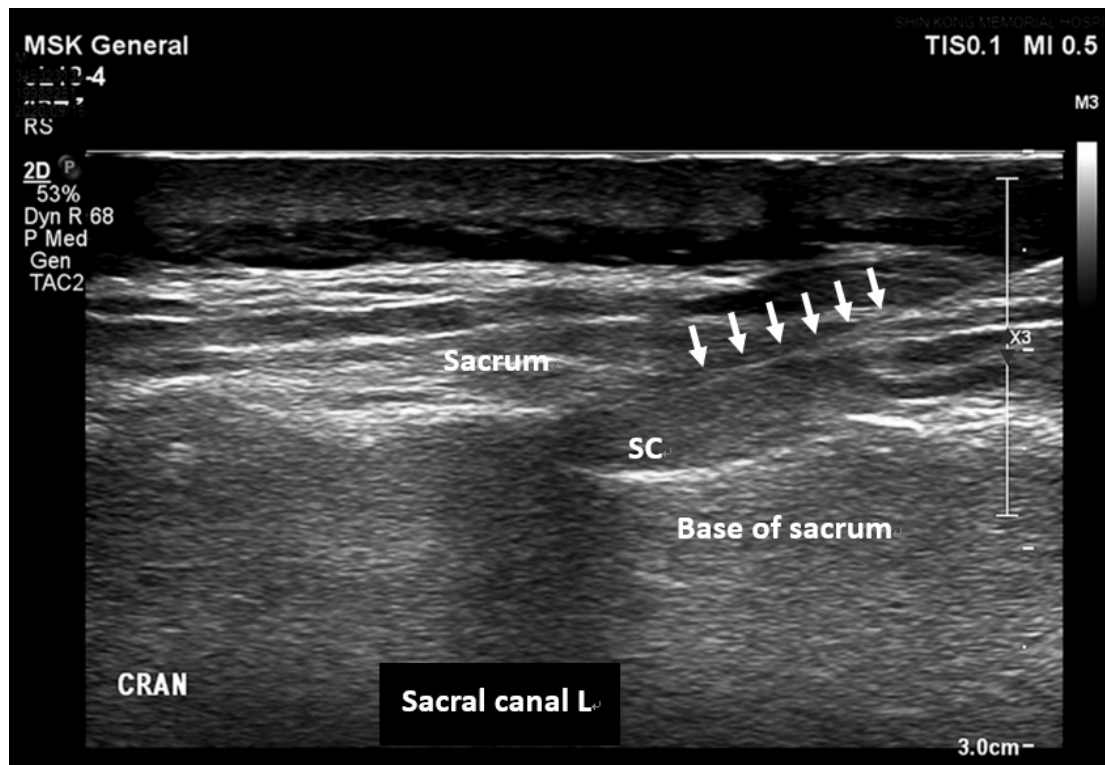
Longitudinal view of the sacral canal during ultrasound-guided caudal epidural block. (White arrow: the needle; SC: sacral canal; CRAN: the cranial side; L: longitudinal view)
